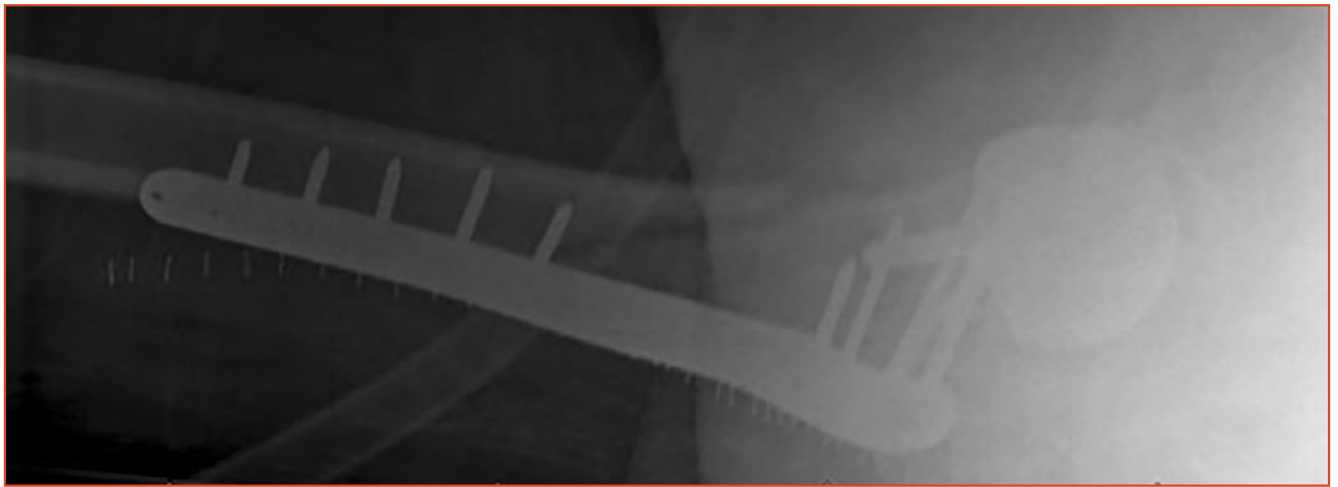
Immediate postoperative lateral radiograph of the right femur, showing a well-reduced fracture with a lateral proximal femoral locking plate in place.
